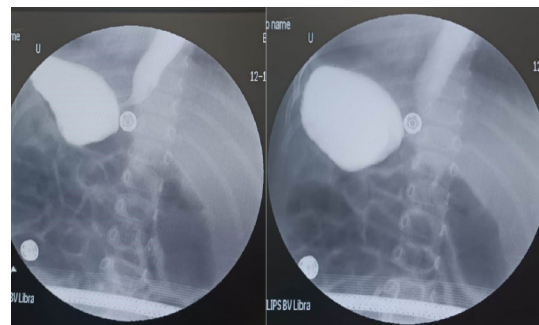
Preoperative contrast radiography of the upper GI tract of Case 2
